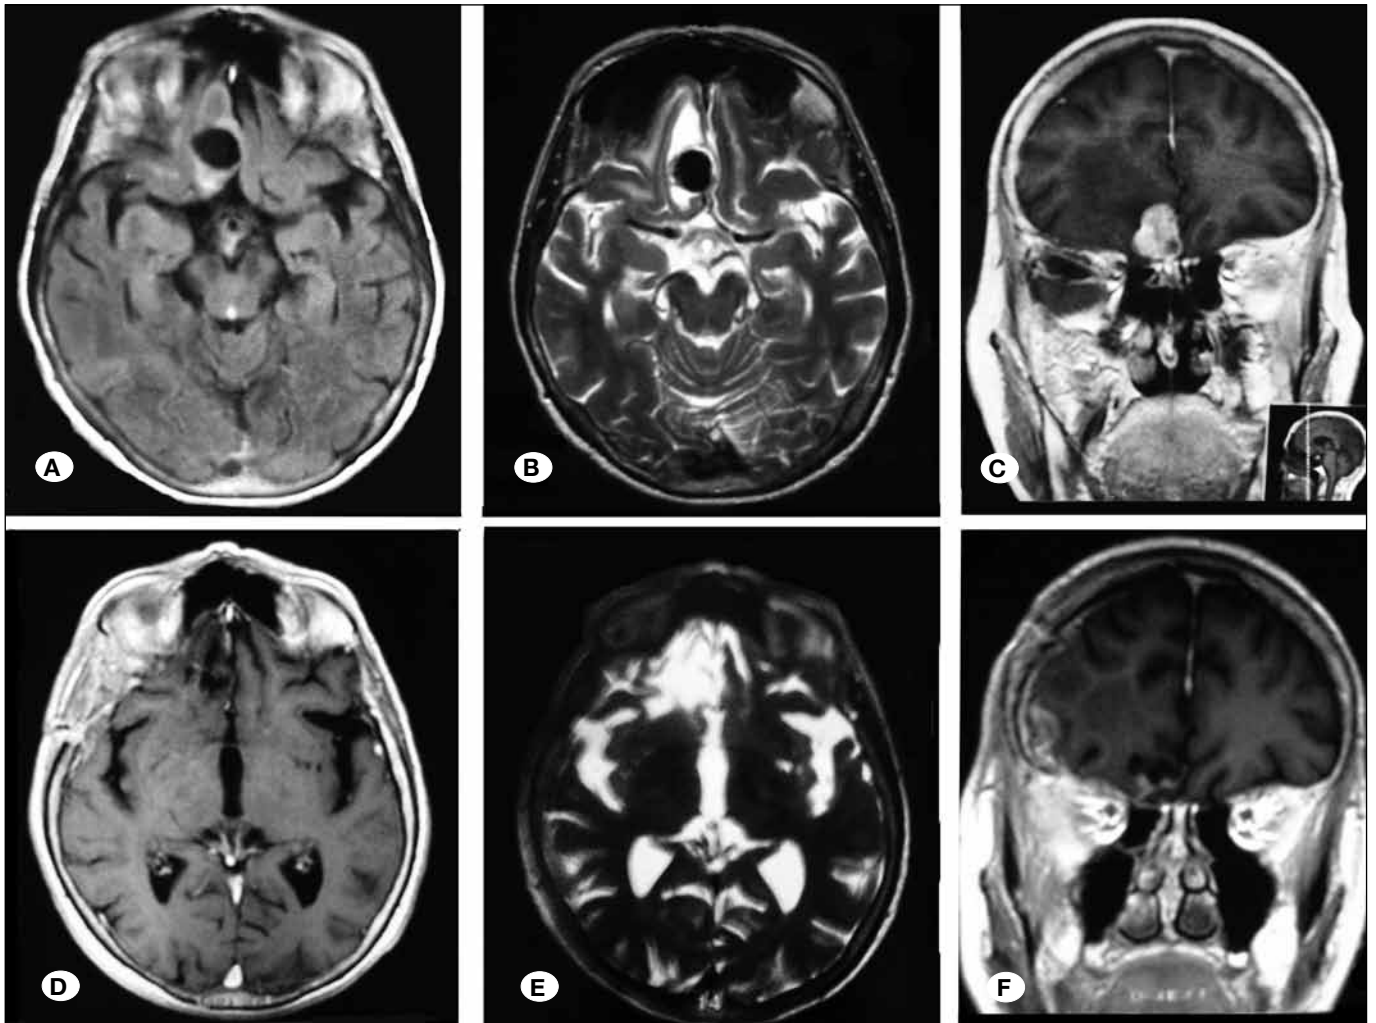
Magnetic Resonance Imaging (MRI) showing an extra-axial mass in the right frontal region near midline and elevating the olfactory bulb: A) Axial T1-weighted, B) axial T2-weighted and C) coronal T1-weighted preoperative MRI; D) Axial T1-weighted, E) axial T2-weighted and F) coronal T1-weighted postoperative MRI.
